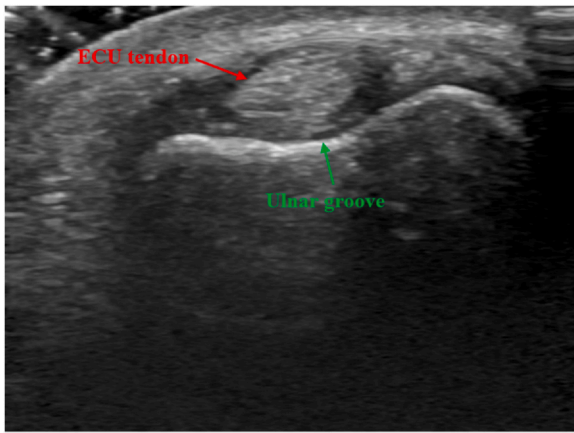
Transverse ultrasound cross-section of the extensor carpi ulnaris (ECU) tendon as it sits within the ulnar groove during neutral forearm rotation.
